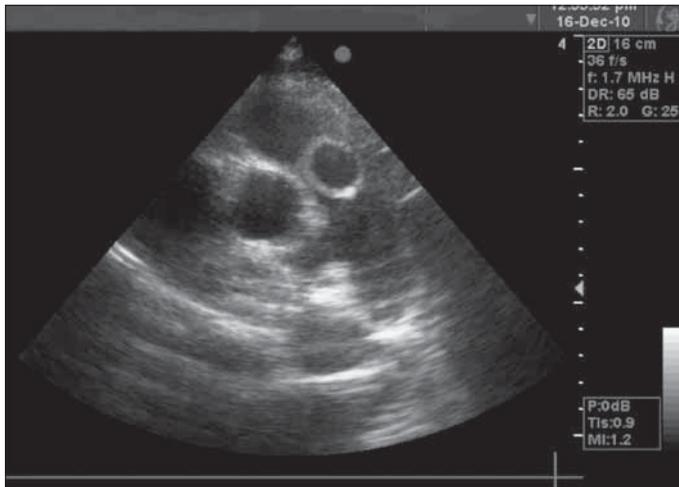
Short- axis echocardiography view of pulmonary artery cyst at the level of the pulmonary valve
